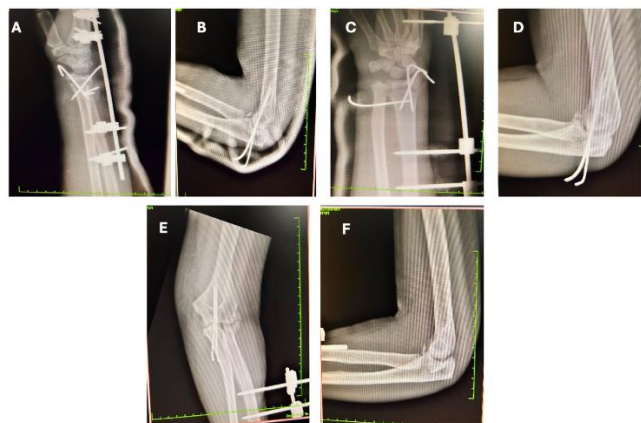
A-B): Primary surgical radiographs; C): Negative ulnar variance restored; D): 4-weeks before removal of ulno-humeral K wire in Lateral view; E): 4-weeks before removal of ulno-humeral K-wire in Antero-posterior view; F): 2-weeks after removal of ulno-humeral K-wire
